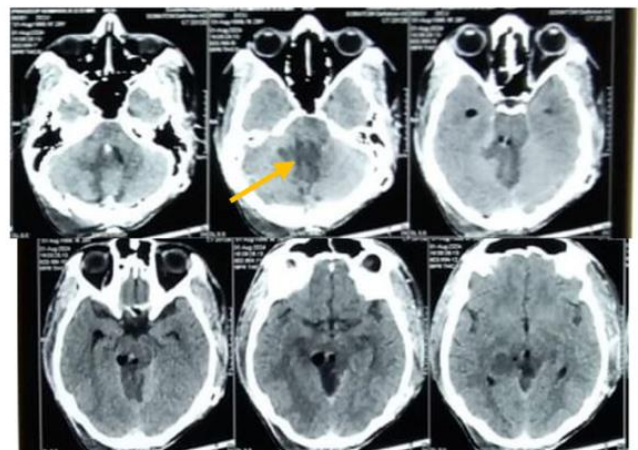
Post-op CT showing Ischemic changes in the Cerebellar vermis and the focus of adjacent right cerebellar hemisphere. (Yellow arrow)
